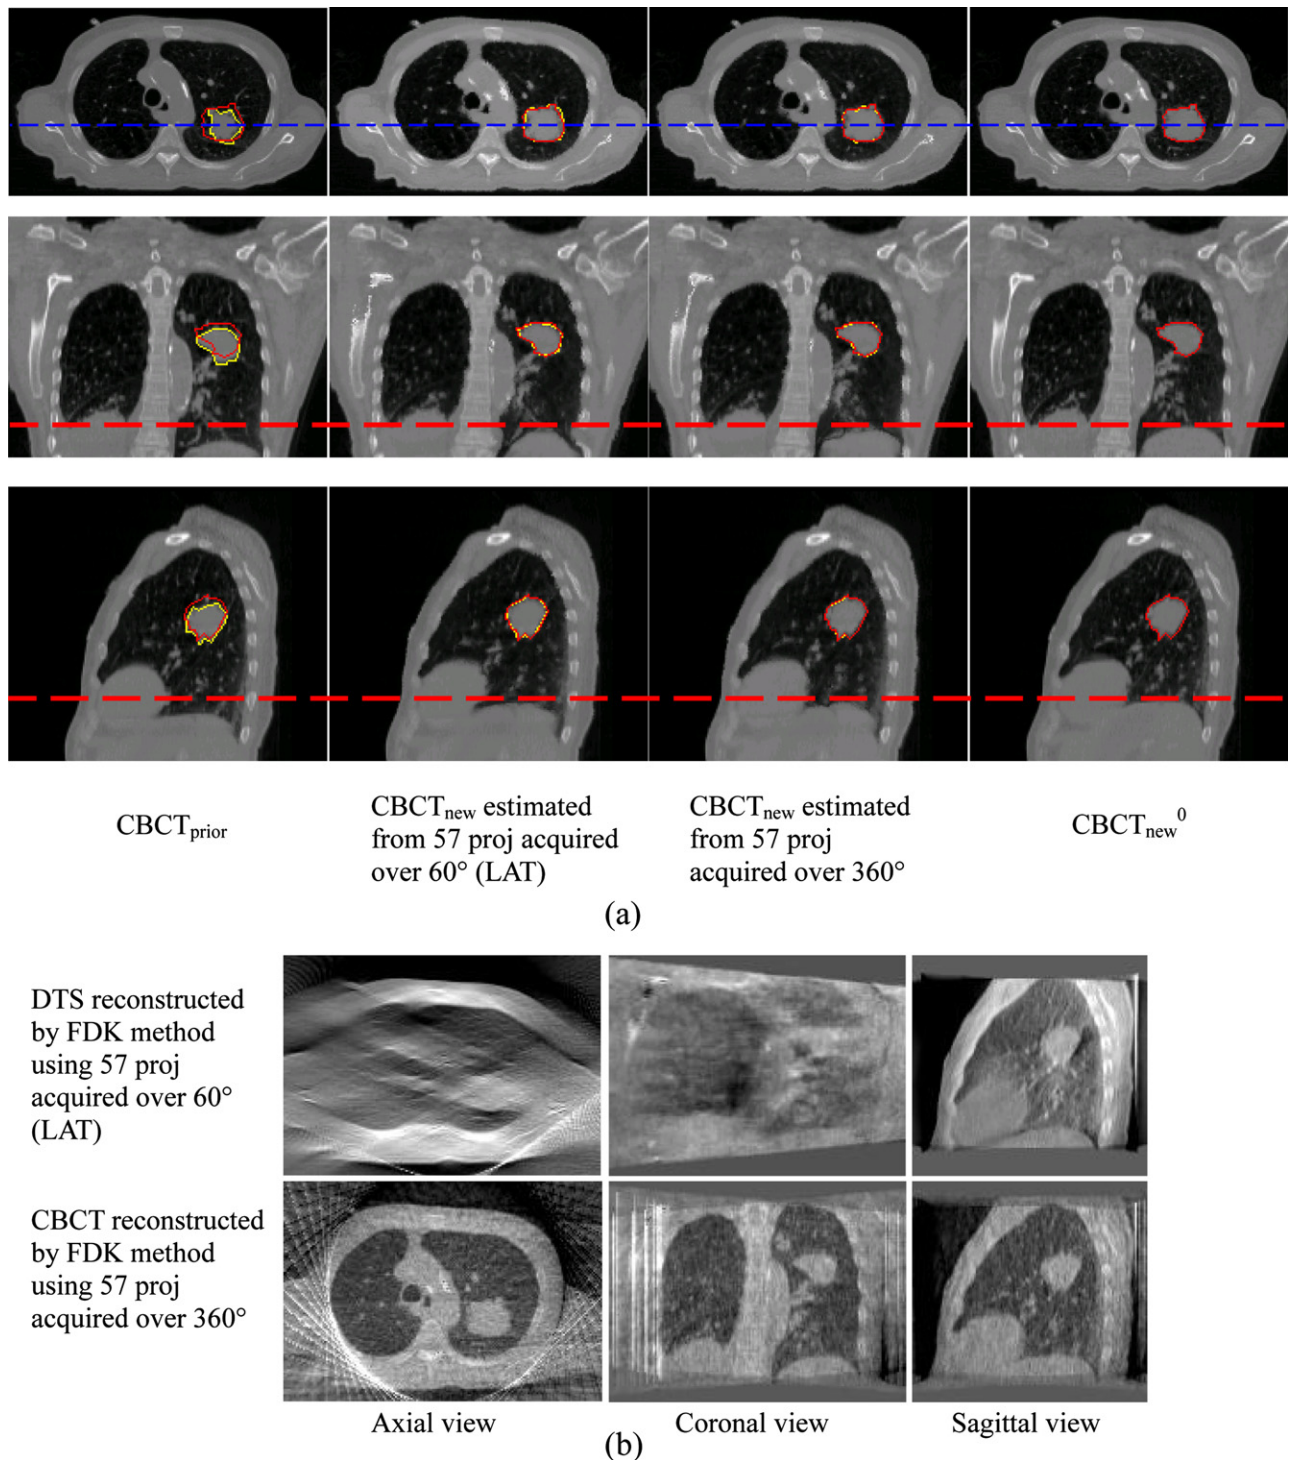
Prior image-based and Feldkamp–Davis–Kress (FDK) method-based  $CBCT_{new}$  images of lung cancer patient data. In the axial, coronal, and sagittal view images in (a), the contours of the lung tumor in  $CBCT_{new}$  (red contours) are overlaid onto  $CBCT_{prior}$  and estimated  $CBCT_{new}$  images for comparison with the lung tumor contours in these images (yellow contours). In coronal and sagittal view images in (a), the dashed red lines indicate the height of the diaphragm in  $CBCT_{new}^0$ . CBCT = cone-beam computed tomography.
